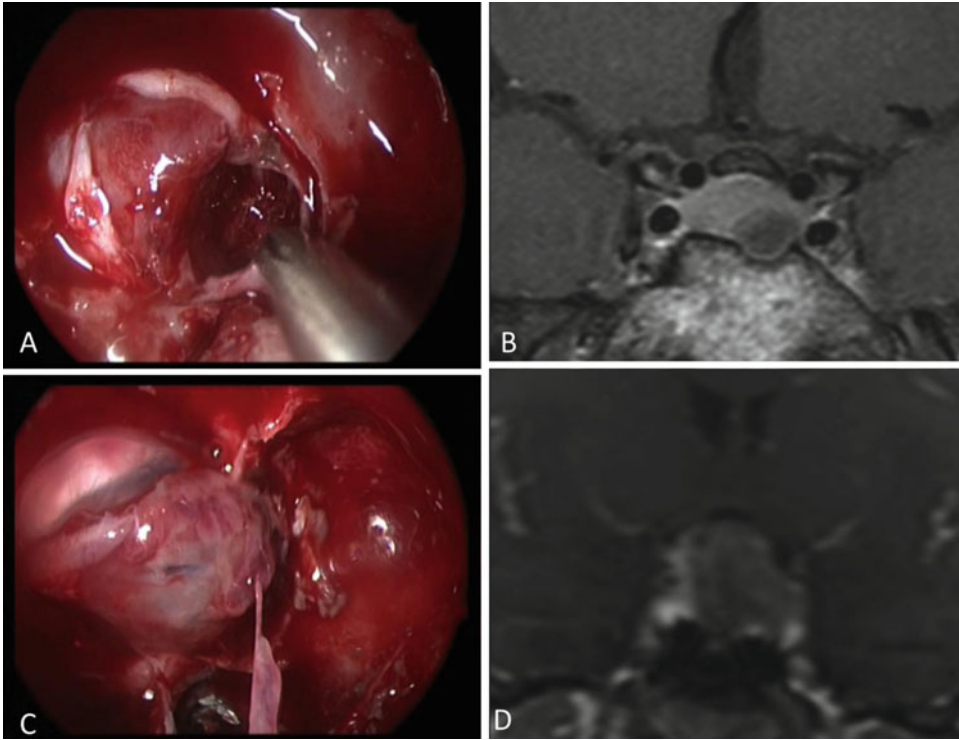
(a, b) Intraoperative view of microcapsular dissection and MRI of the patient demonstrating the microadenoma (c, d): Intraoperative view of macrocapsular dissection and MRI of the patient demonstrating the macroadenoma
